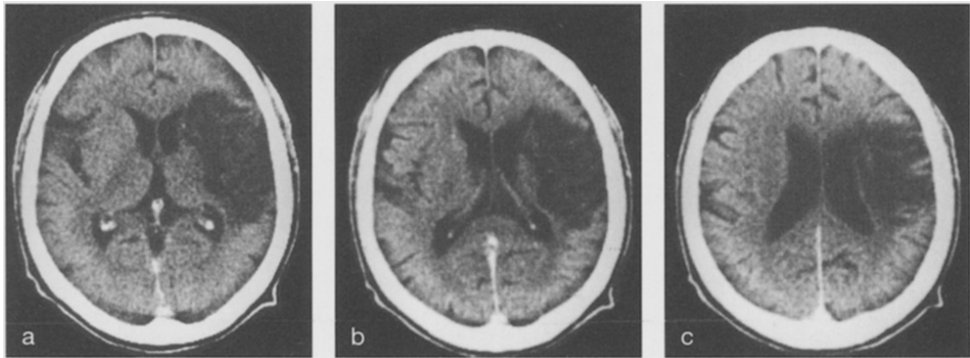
CT Scan of patient NL, which shows an ischemic lesion in the right parietal lobe.
